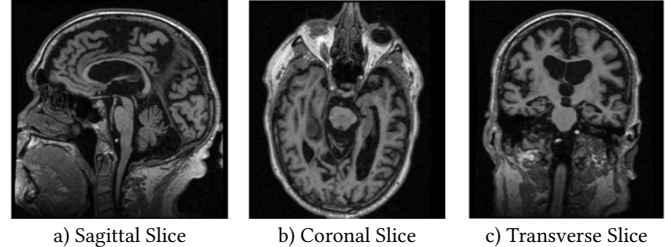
Sample views of MRI images from the ADNI database.
